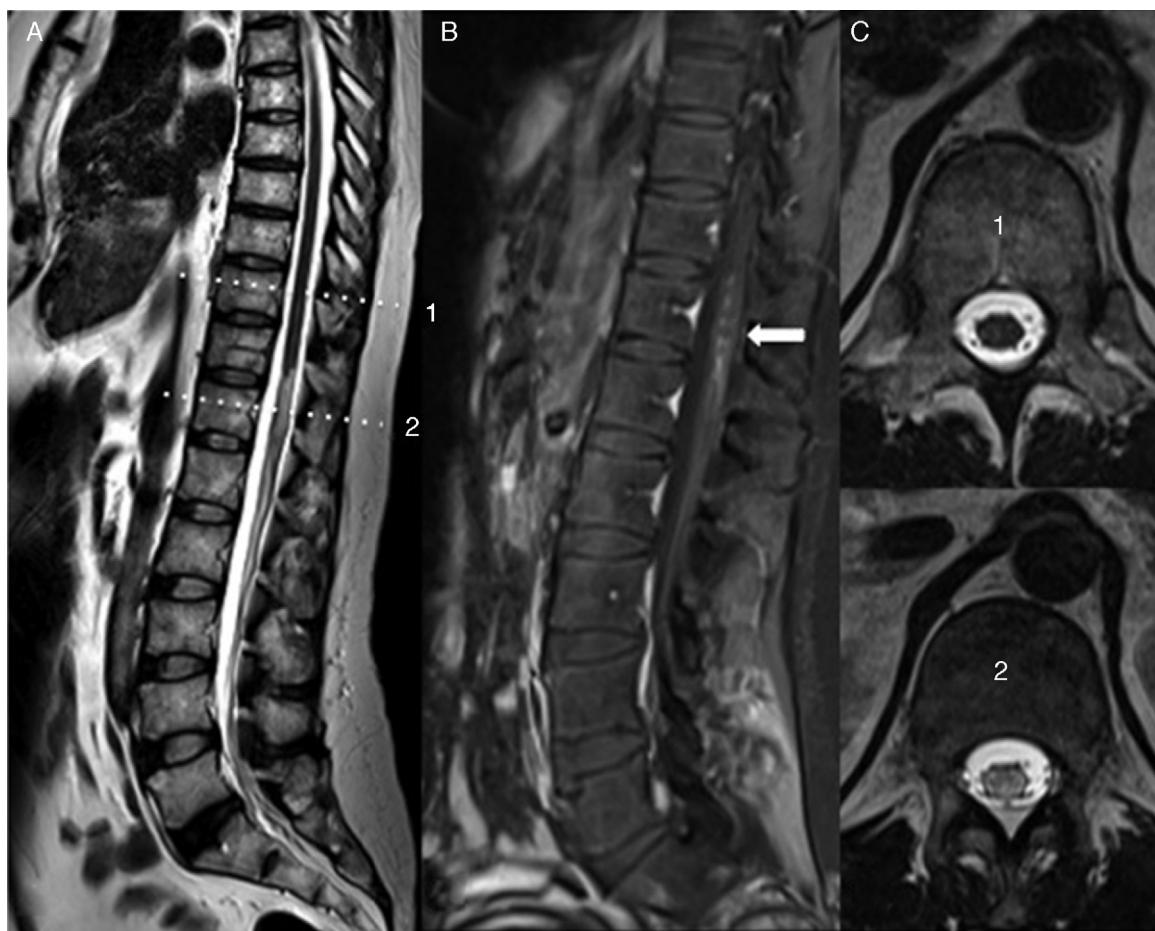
Sagittal T2-weighted image, showing hyperintensity and mild enlargement of spinal cord volume, extending from T11 to the medullary cone. B, T1-weighted sagittal image after contrast injection, with foci of medullary enhancement (arrow) extending from T11 to L1. C, Axial T2-weighted images demonstrating the spinal cord with a normal signal obtained at the T10 level (1) and spinal cord with hyperintensity obtained at the level of T12 (2).
